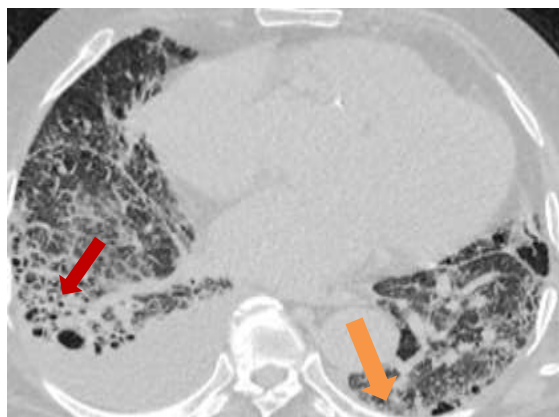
Axial HRCT image of the chest showing HRCT findings in IPF patient including...bilateral diffuse centrilobular and subpleural pulmonary reticulations (red arrows) and honeycombing (orange arrow).
